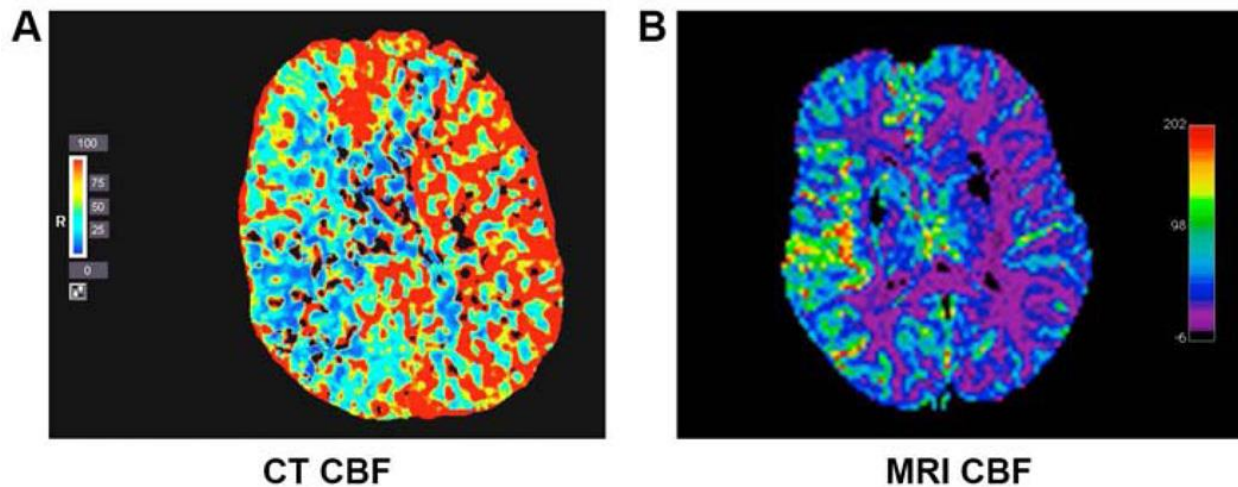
(A) CT of patient presenting with acute right MCA stroke with blue color demonstrating most severely decreased CBF in ischemic hemisphere. (B) MRI of patient presenting with acute left MCA stroke with purple color demonstrating most severely decreased CBF in ischemic hemisphere.
